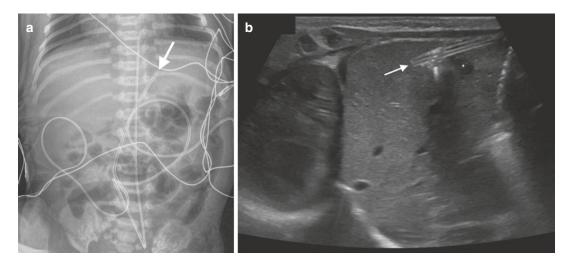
Malpositioned UVC. (a) Chest radiograph demonstrates a UVC with tip overlying the left hepatic lobe (arrow). (b) US image shows the UVC catheter within the liver parenchyma (arrow). Note the small adjacent fluid collection (*)
